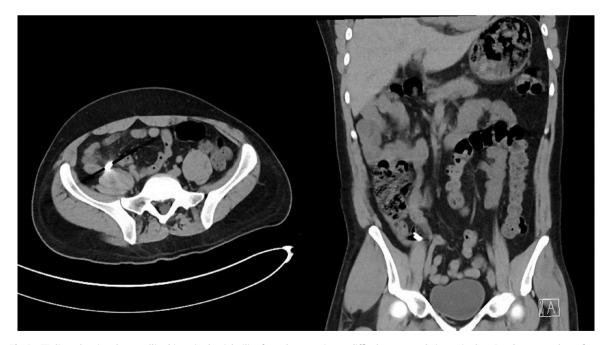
CT slices showing the metallic objects in the right iliac fossa, however it was difficult to assess their precise location due to streak artefacts.
